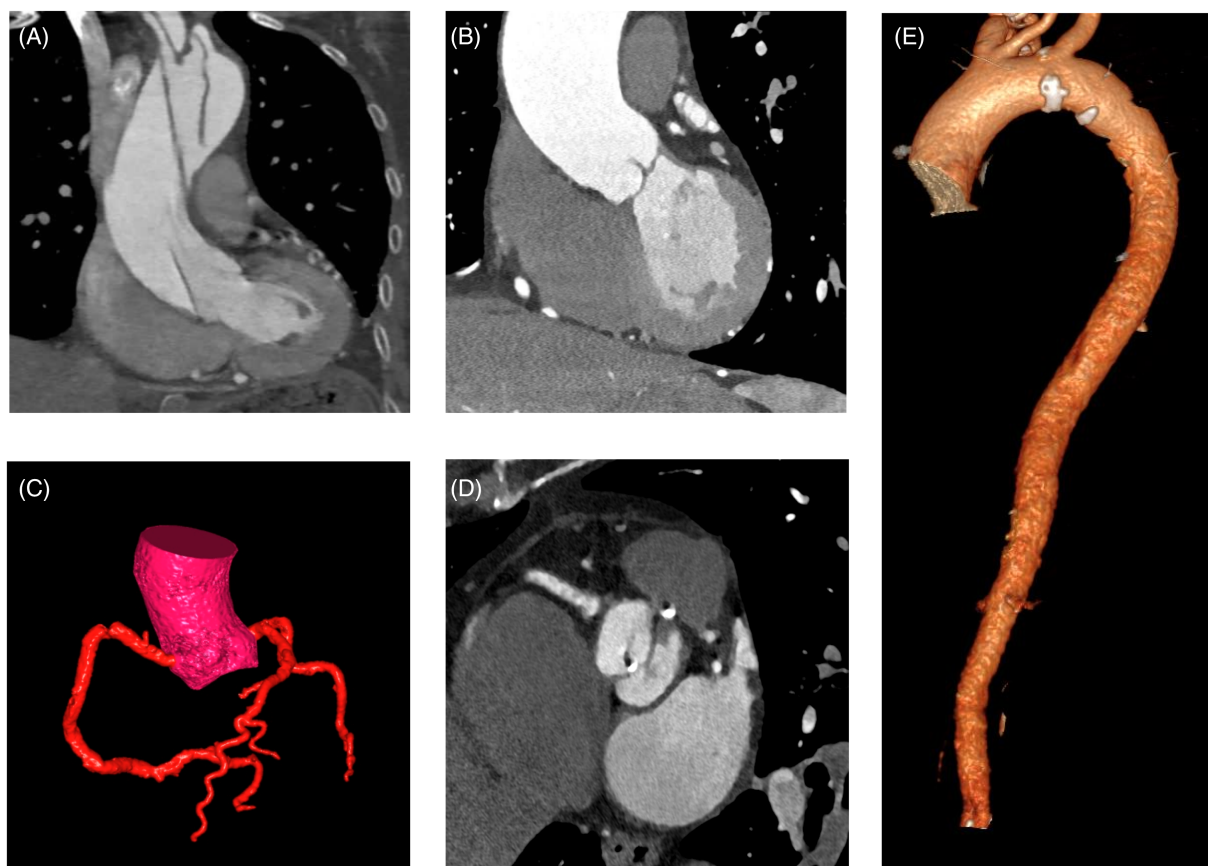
Computed tomography assessment of aortic regurgitation. (A) type A aortic dissection in a patient with AR, (B) aorta ascendens dilatation in a patient with moderate AR (C), volume rendering of the coronary arteries, (D) Bicuspid aortic valve with degeneration of the valve leaflets, (E) volume rendering of the thoracoabdominal aorta. AR, aortic RegurgitationFlow
